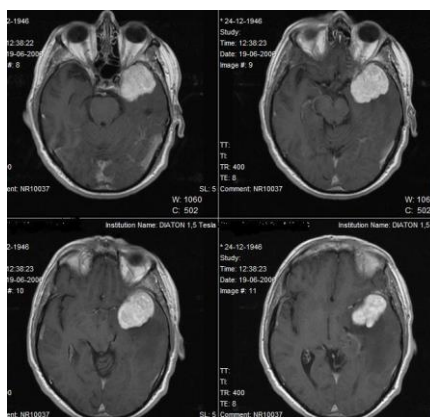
T1-weighted MRI (with gadolinium contrast) showing the SFT of the presented patient before the first surgery (GTR).
